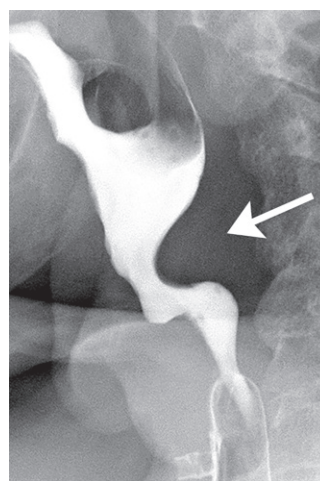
PES dysmotility in a 72-year-old woman. Lateral radiograph of swallowing shows PES narrowing during the passage of the bolus (arrow).
